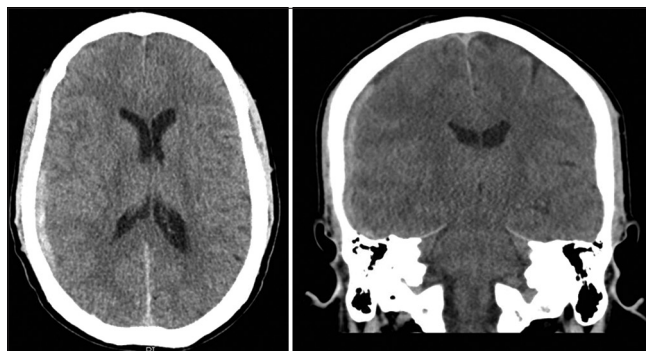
Outside hospital head computed tomography demonstrating a right convexity mixed density subdural hematoma, axial (left), and coronal (right) views.
